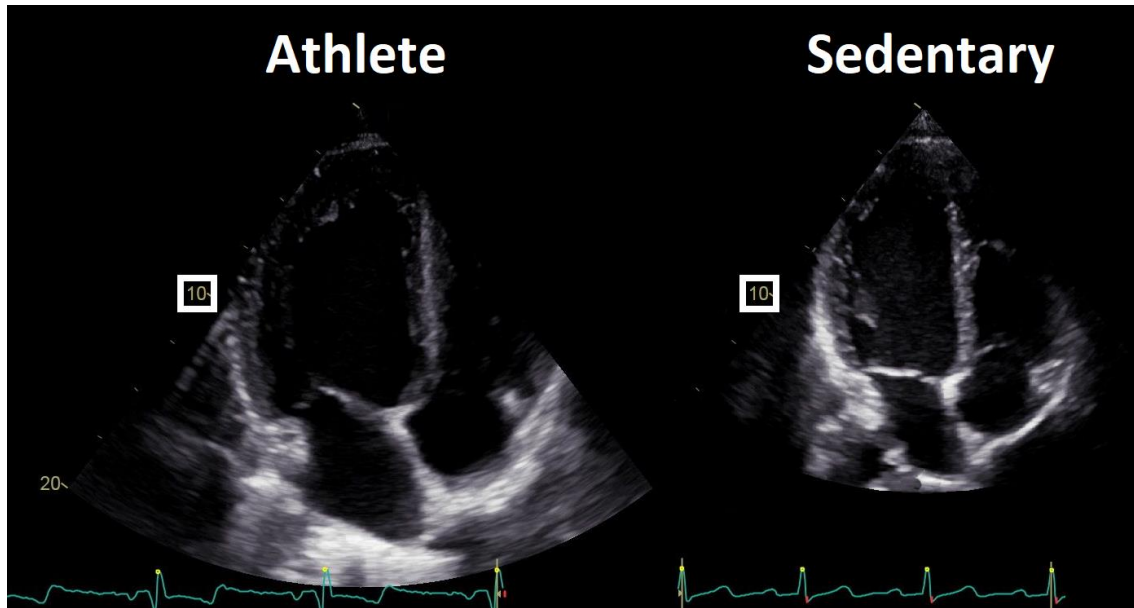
Left ventricular and atrial adaptation in athletes. Two echocardiograms (apical four-chamber view) are shown, a professional male athlete (swimmer, 25 hours of training/week), and a sedentary male with comparable height. Note the spectacular difference in chamber dimensions.
